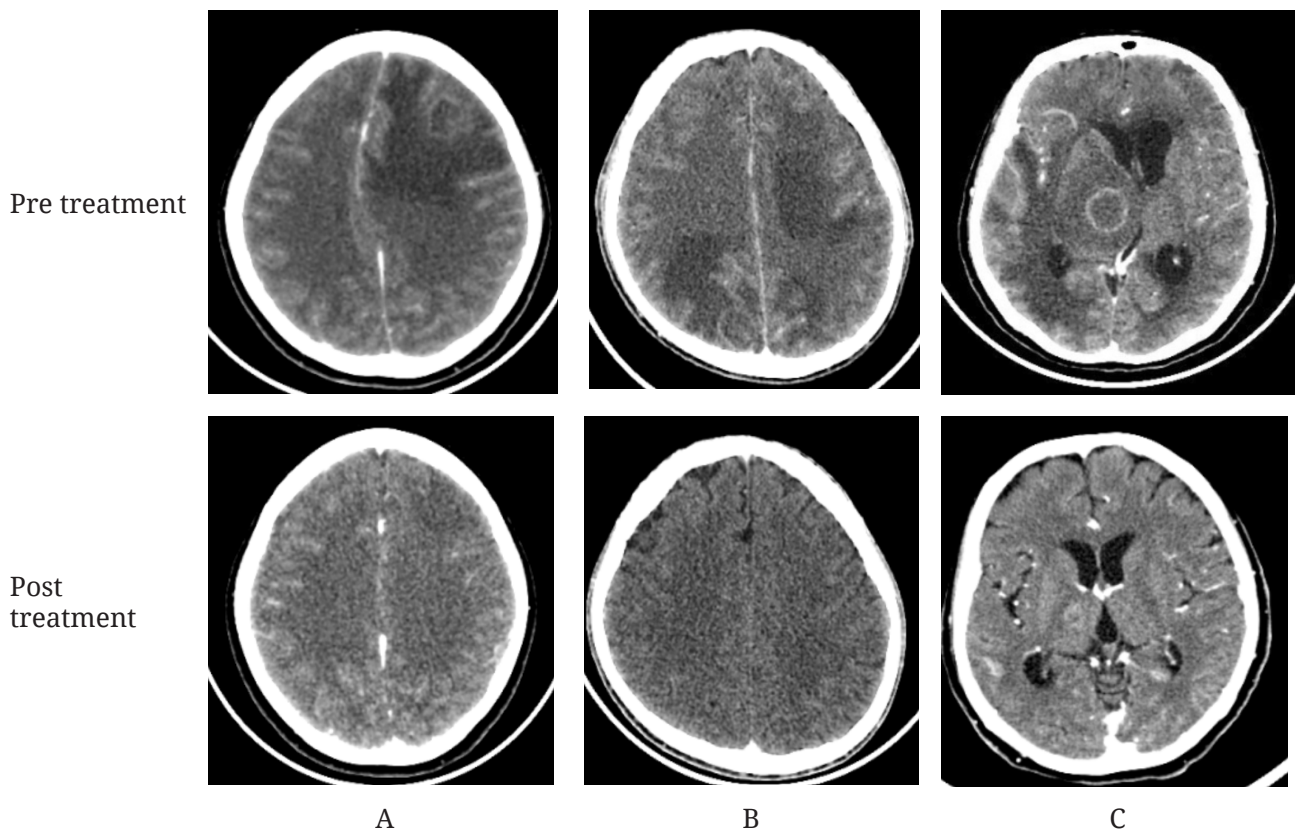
Pre- and post-treatment contrast head CT scans showing ring enhancing lesion surrounded by perifocal edema suggestive to toxoplasma encephalitis; A) cortical lesion; B) cortical and cortico-medullary junction lesions; C) basal ganglia lesion.
